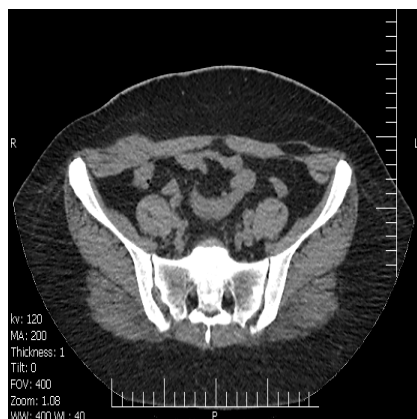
Computed tomogram of the abdomen and pelvis.
